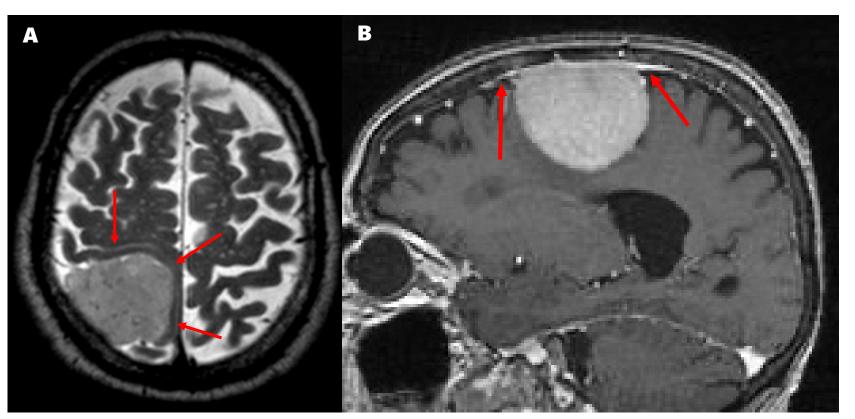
Characteristic MRI features of meningioma. (A) Axial T2-weighted image shows medial displacement of grey matter (arrows) by the meningioma (asterisk). (B) Contrast-enhanced sagittal T1-weighted image shows homogeneous enhancement and a broad dural base or a dural tail (arrows).
